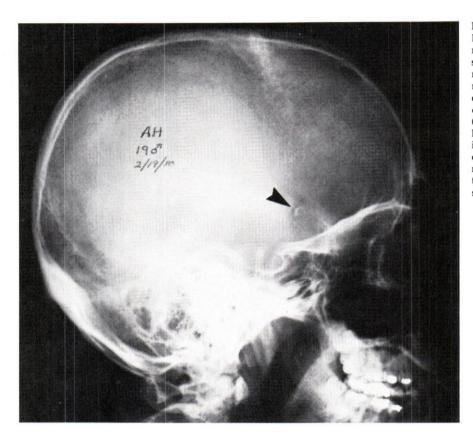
Lateral radiograph of the skull of a nineteen year old man in whom osteomyelitis developed (arrow) from a halo pin-site infection. A craniotomy was required to drain the resulting subdural abscess.
